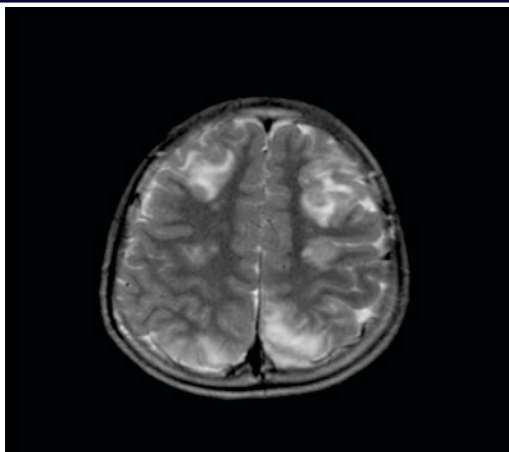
bilateral fairly symmetrical homogenous confluent T2/FLAIR hyperintensity involving cortical and subcortical regions of frontal, parietal and occipital lobes suggestive of PRES
